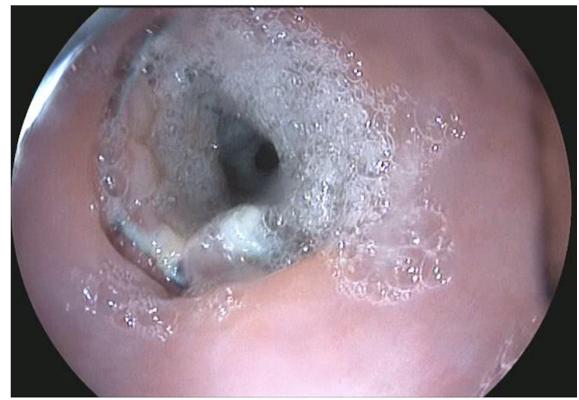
The image on the left corresponds to a CT scan performed immediately after placement of the partially covered Ultraflex esophageal stent. Water-soluble contrast that do not extravasate outside the stent can be observed. The arrow indicates the location of the esophageal stricture. Pneumomediastinum can also be seen. In the right column, from top to bottom: upper end of the stent after 15 days of being in place. The stent could be easily removed by pulling the string with foreign body forceps. After its removal mucosal hyperplasia induced by the uncovered part of the stent is observed. This hyperplasia prevented stent migration.
